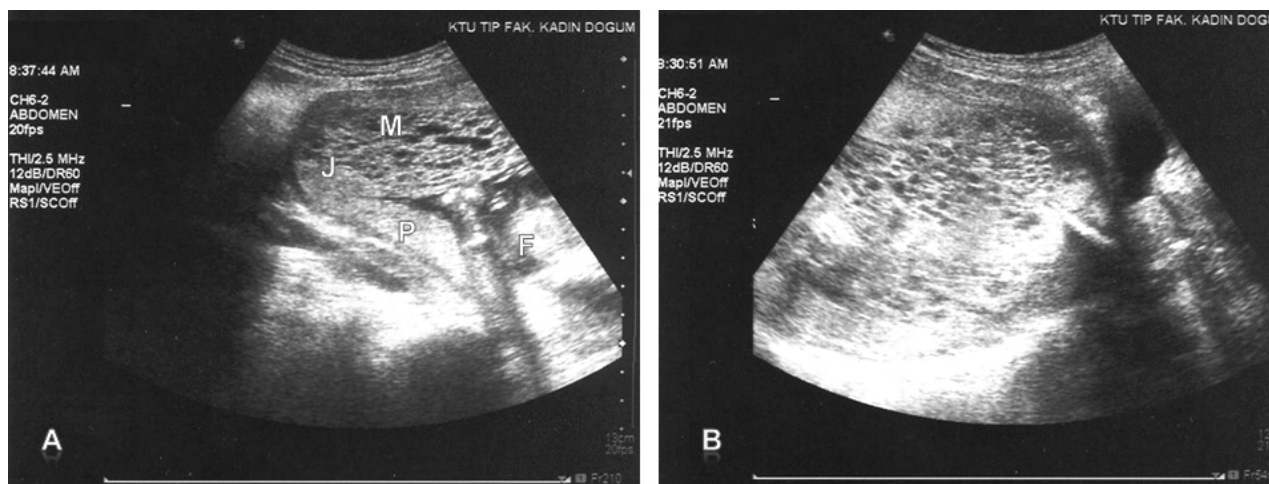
(A) Sonographic appearance at 14 weeks of a twin pregnancy with co-existing hydatiform mole. P, normal placenta, F, fetus, M, area of hydatiform mole, J, junction of normal abnormal placenta. (B) Central heterogeneous mass with numerous discrete anechoic spaces which correspond to diffuse hydatidiform swelling of the hydropic chorionic villi “snowstorm pattern”.
